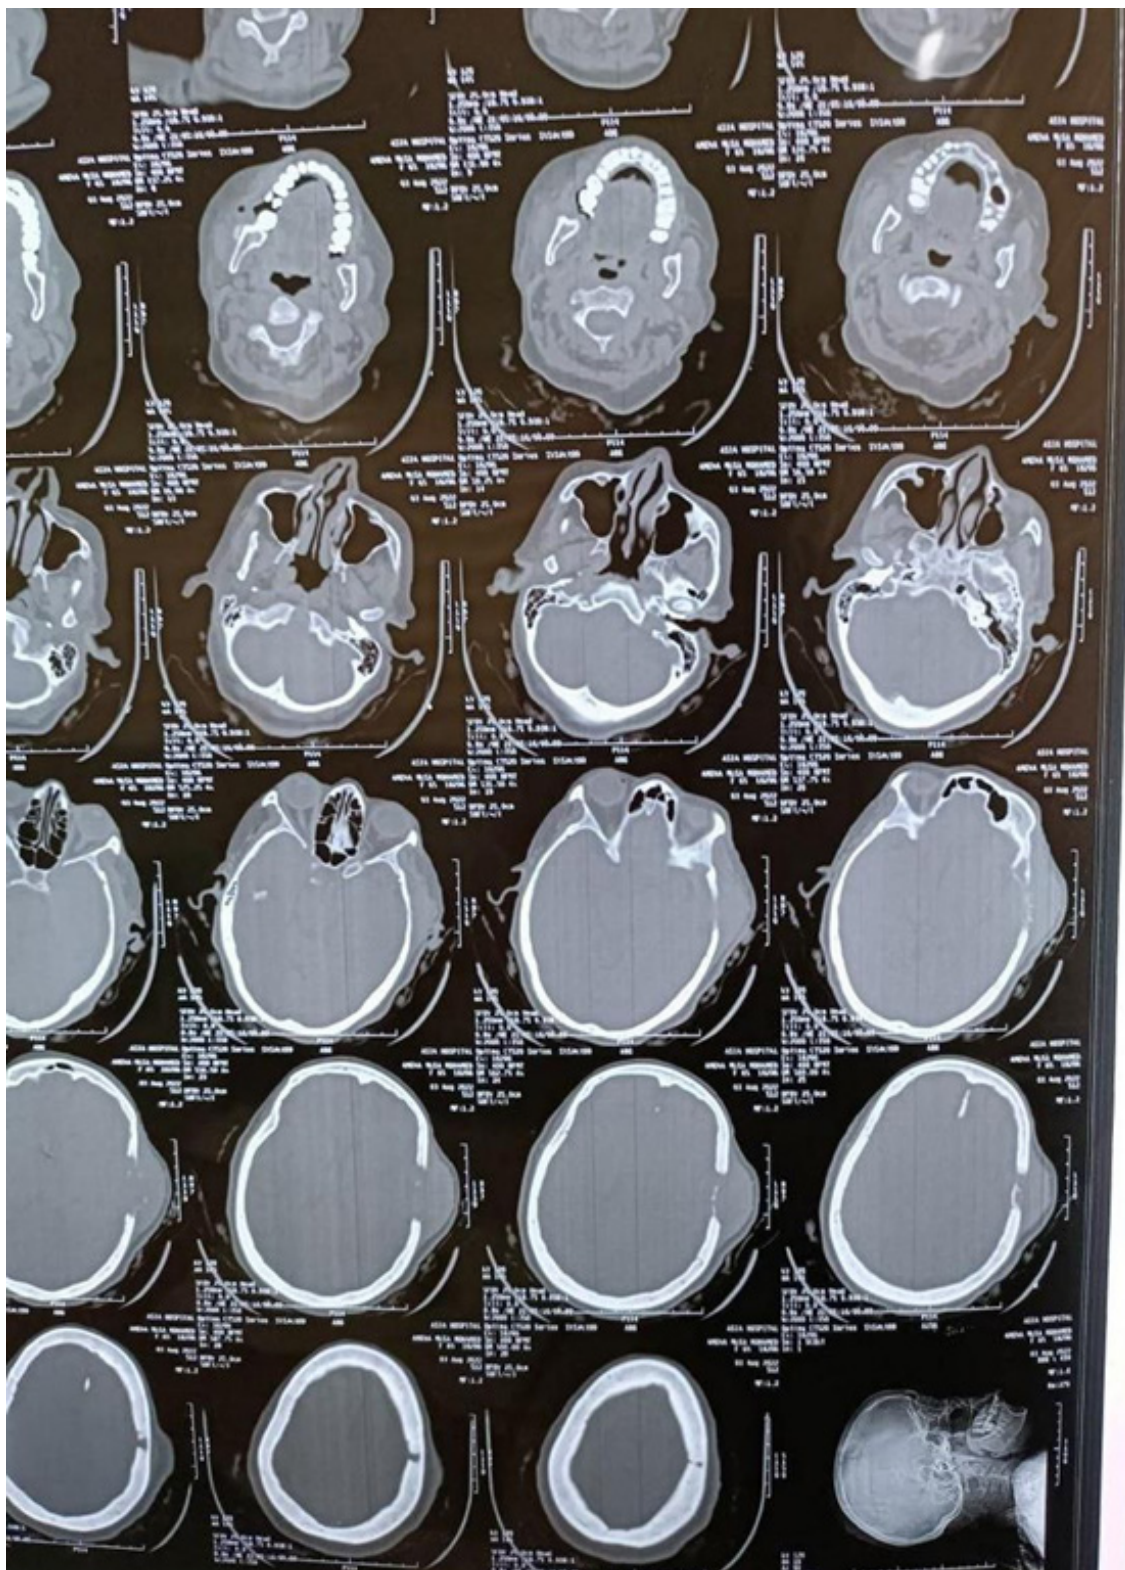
CT brain, axial cut, bone window shows the bony defect caused by the lesion at the left temporo-parietal bones.
